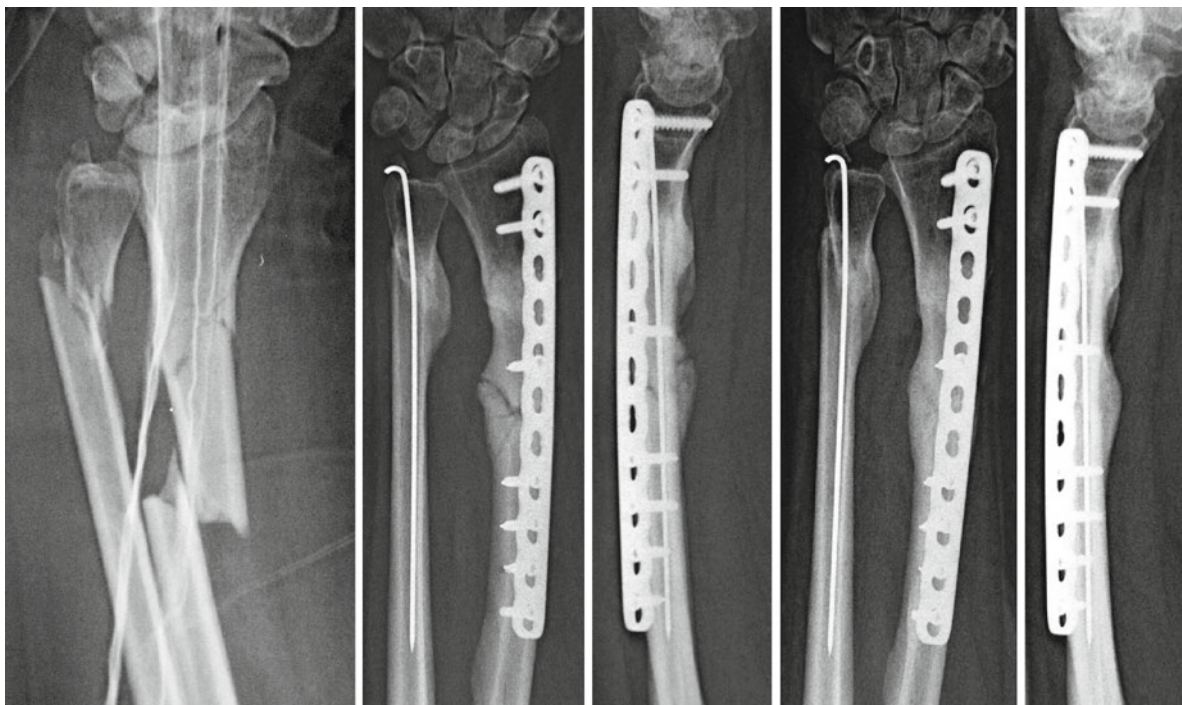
Multiple-injured patient. Segmental fracture of the radius and distal ulna fracture. X-rays 6 weeks and 1 year after accident
